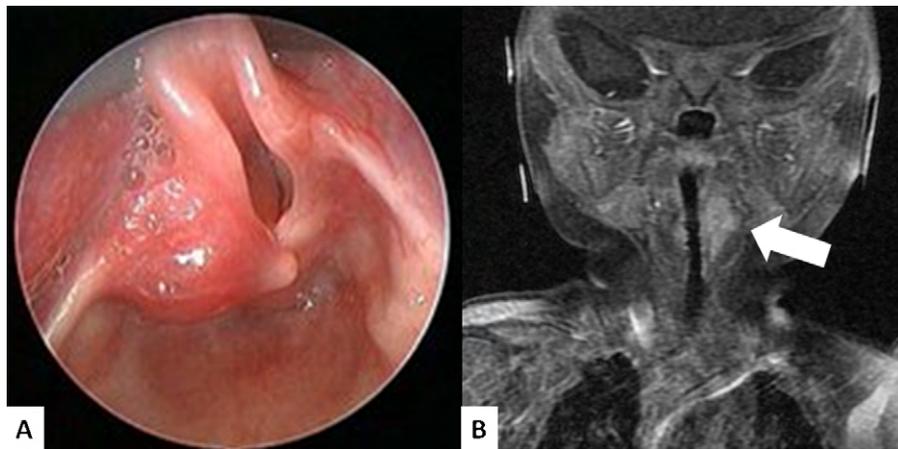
Patient 5 direct laryngoscopy. Supraglottic hemangioma located along the right aryepiglottic fold and anterior surface of the epiglottis compressing on the supraglottic airway (A). On coronal imaging MRI, the lesion is seen extending into paraglottic space (arrow) and possibly to the contralateral paraglottic space (B). Post propranolol imaging not available.
